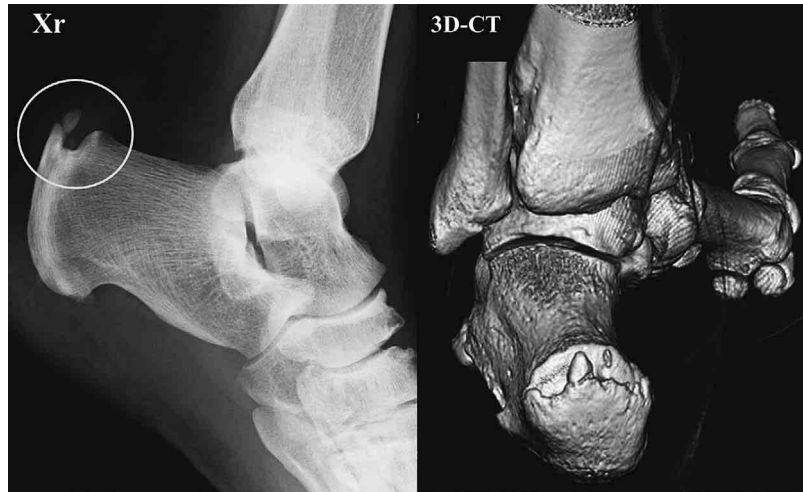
Plain radiograph reveals Haglund's deformity, calcaneal exostosis, fracture of the exostosis and bone fragment in the Achilles tendon (circle). 3D-CT revealed a wide calcaneal exostosis.
